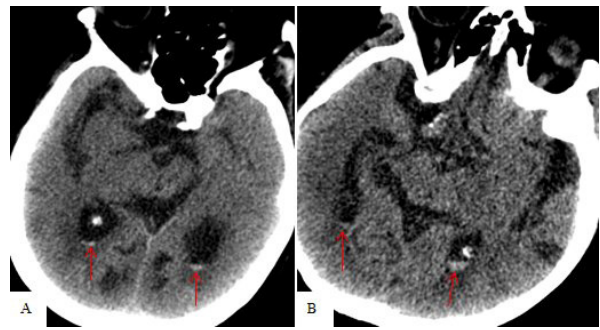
A 78-year-old female patient under anticoagulation (A) and a 81 year old female patient without prophylactic anticoagulation presented with COVID-19 pneumonia and followed in ICU. Axial CT images show small amounts of IVH (A,B, red arrows) without obvious parenchymal hemorrhage
